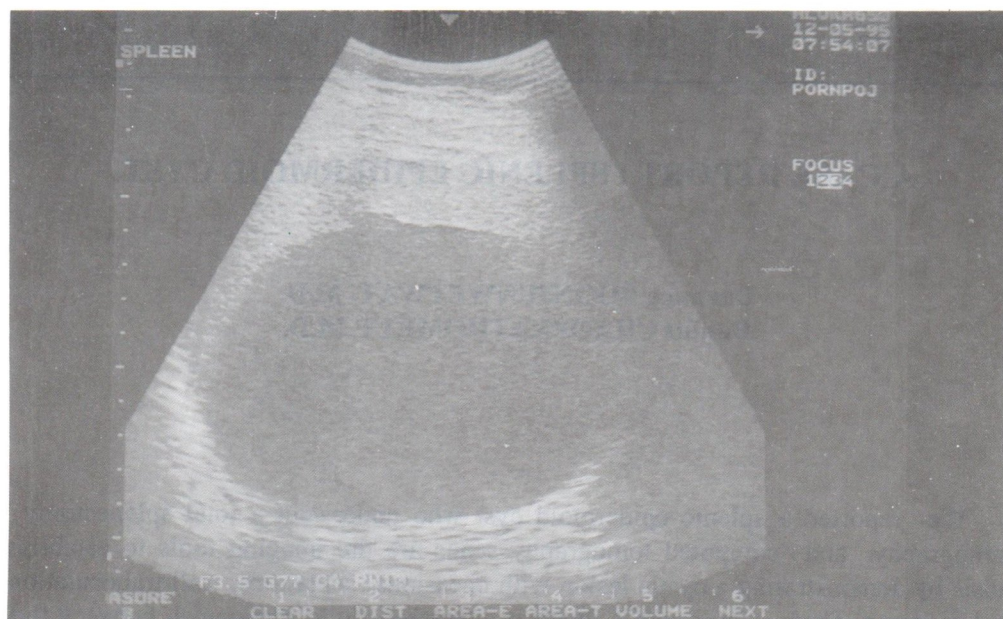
Abdominal sonography showed an echo-free area with smooth, sharp border and enhancement of the echoes deep to the lesion occupying in the spleen about 12.2 x 8.7 cm².
